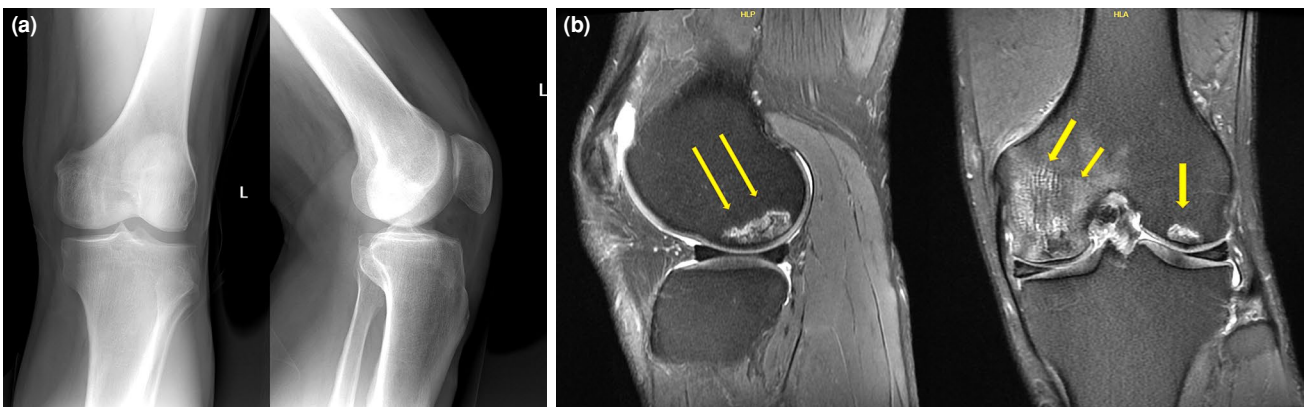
A relatively normal X-ray of a patient's knee (a) exhibiting clear signs of osteonecrosis of magnetic resonance imaging. The "double density sign" with an external low signal intensity rim and a high signal intensity internal rim on the T2 images (arrows) can be observed (b).
